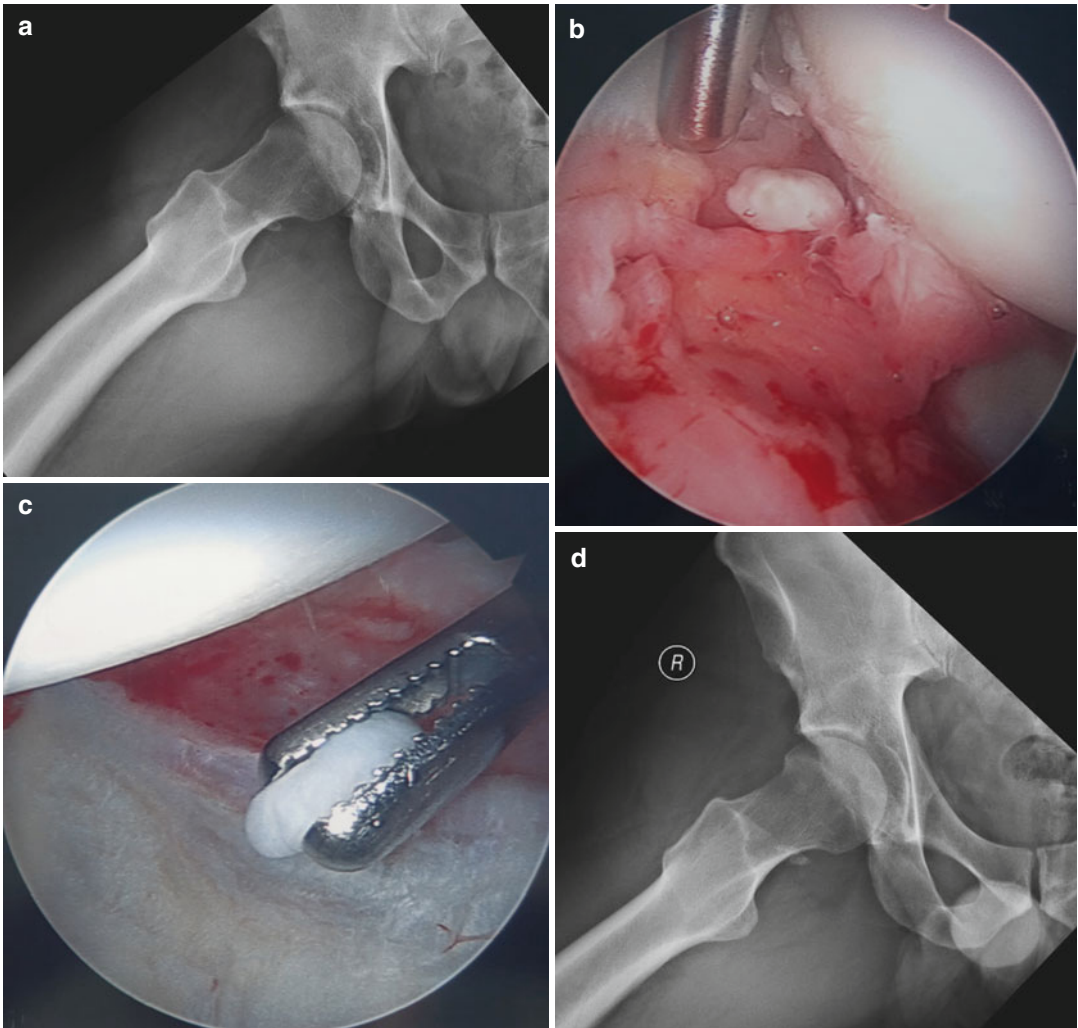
(a) Radiograph showing loose bodies. (b, c) Arthroscopic views showing extraction of the central loose bodies. (d) Postoperative radiograph showing that the fragments have been removed
